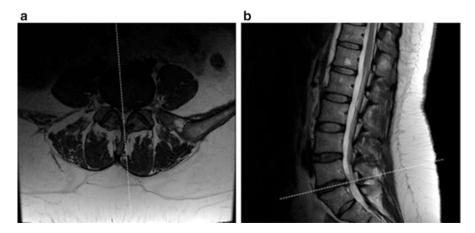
Axial (a) and sagittal (b) T2-weighted MR images of L4-5 right paracentral protrusion
